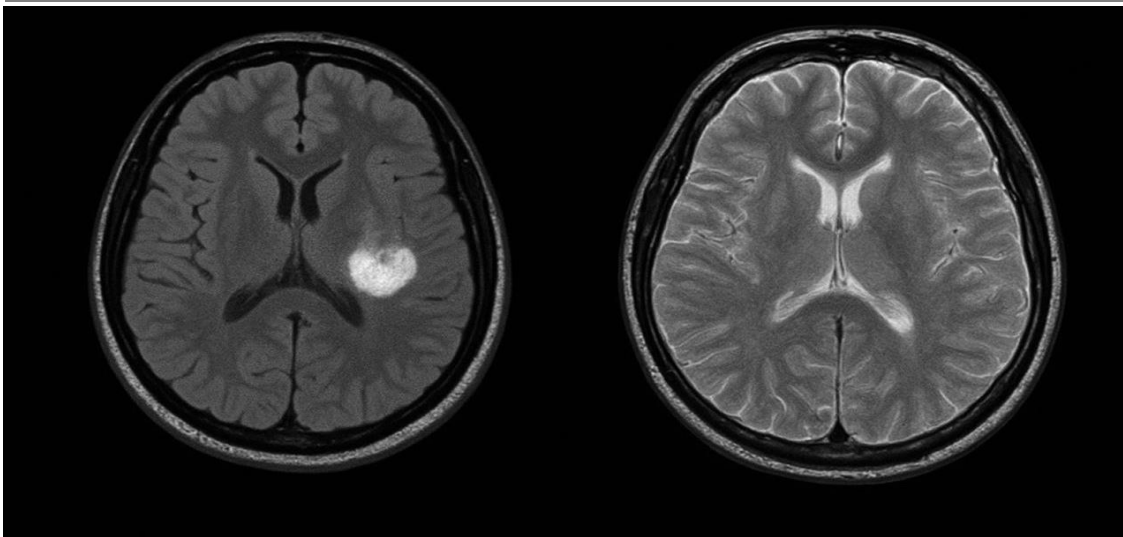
DWI MRI showing hyperintensity in acute ischemic stroke.
